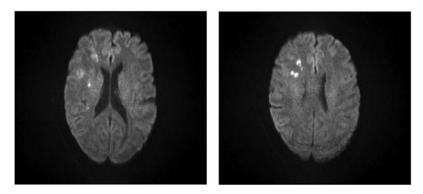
MRI brain. B1000 sequence. Acute infarcts in anterior division R MCA distribution in right frontal lobe white matter.
